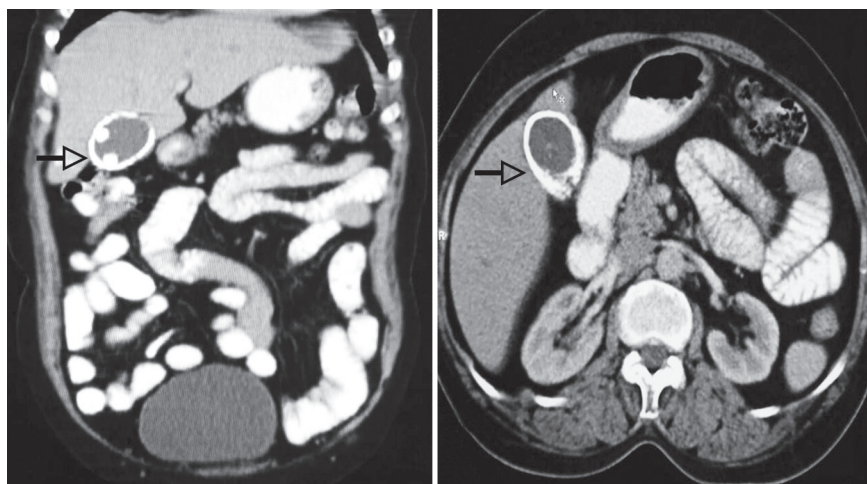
Contrast-enhanced computed tomography of abdomen
